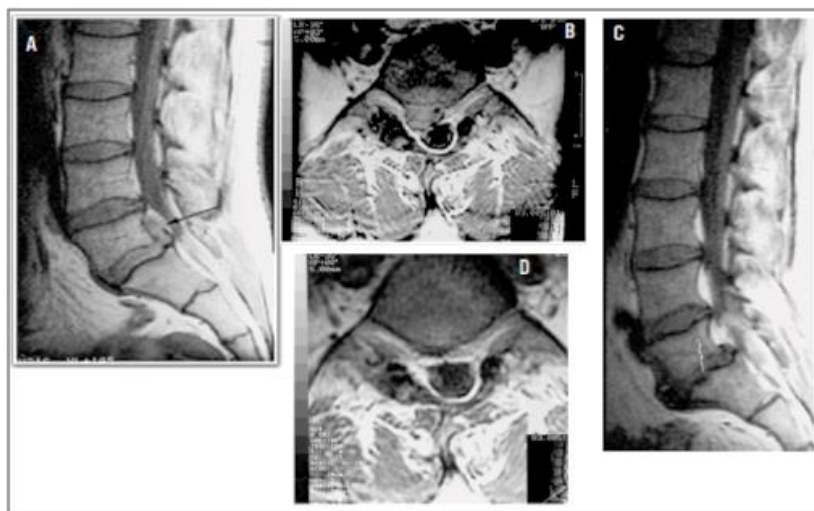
(A, B) Sagittal and axial MRI images showing L5/S1 subligament disc herniation before the start of the recovery programme; (C, D) Sagittal and axial MRI images taken 12 months later, after completing the recovery programme
